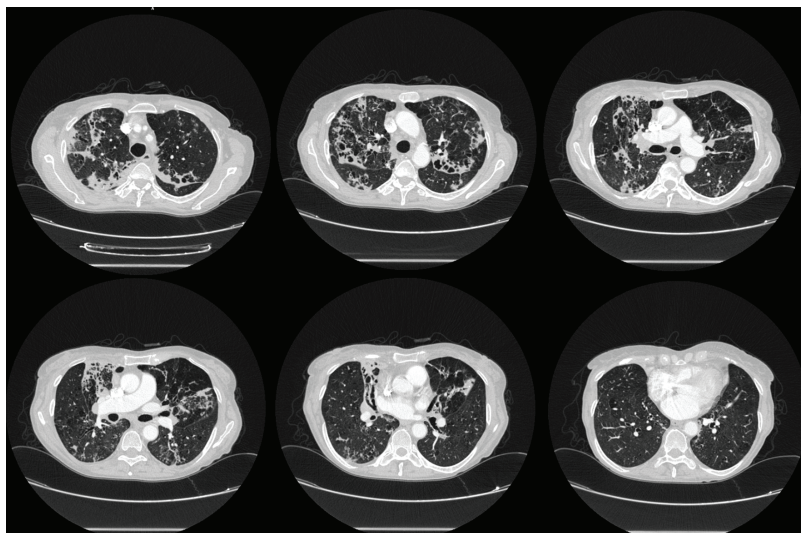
Thoracic computed tomography of the patient revealing bilateral tubular cystic bronchiectasis
